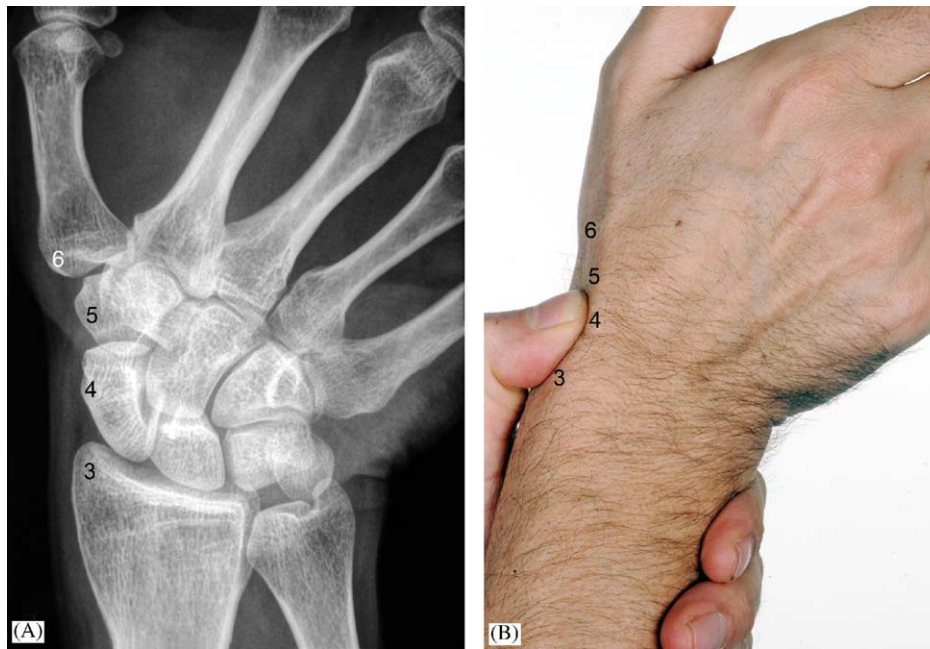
Anatomical snuffbox is revealed better with the wrist in ulnar deviation. (A) X-ray of wrist in ulnar deviation, (B) clinical photograph of wrist in ulnar deviation. Landmarks are—(3) radial styloid, (4) waist of scaphoid, (5) trapezium, (6) base of the first metacarpal.
